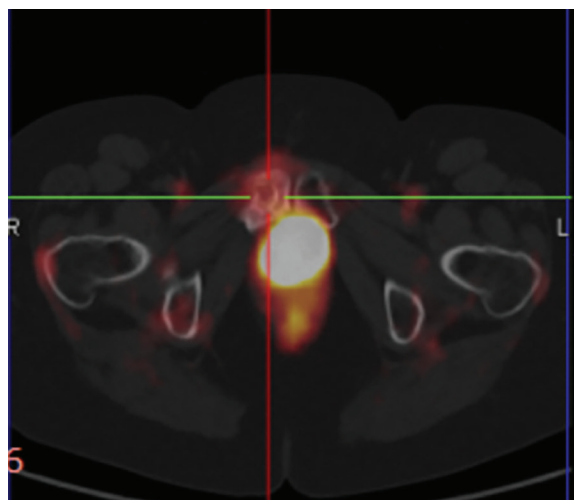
Axial fused PET/CT image obtained 3 months after IRE treatment showing complete metabolic response of the previously treated pubic bone metastasis. No residual FDG uptake is observed at the ablation site, consistent with successful local tumor control. PET/CT, positron emission tomography/computed tomography; IRE, irreversible electroporation; FDG, fluorodeoxyglucose.
